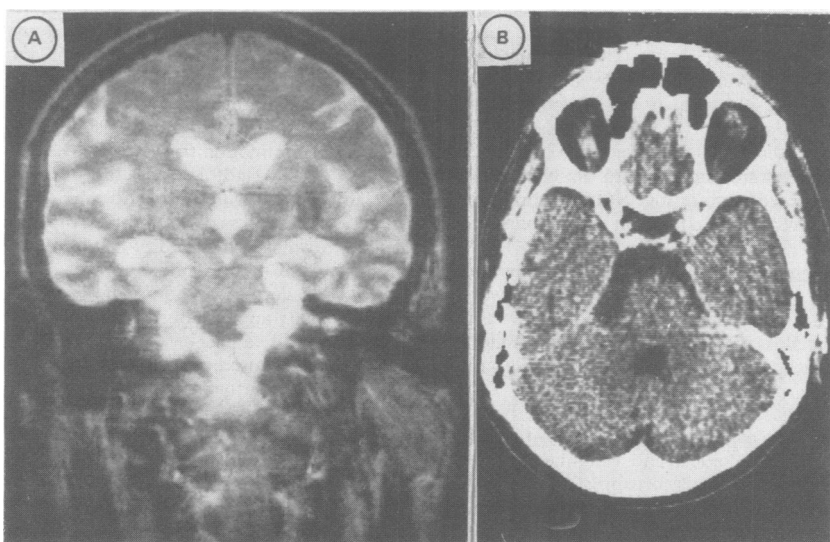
Figure a) MRI (coronal plane, SE 2500/15/90 T2 weighted); b) CT (transverse plane). Neuroradiological findings only disclosed an asymmetrical widened interpeduncular cistern and a cerebellopontine cistern on the left side without contrast media or Gd DPTA enhancement.
